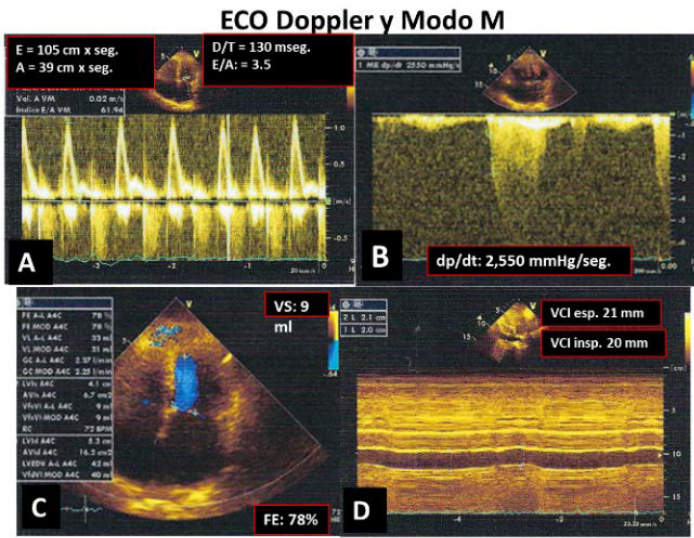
A) Pulsed Doppler, transmitral flow demonstrating a severely restrictive pattern with an E/A ratio of 3.5 and a very rapid deceleration of 130 msec. B) Continuous Doppler of 2,550 mmHg/sec. C) EF of 78%. D) Inferior vena cava expiration and inspiration demonstrates the presence of capillary and systemic venous hypertension due to extreme diastolic heart failure.
